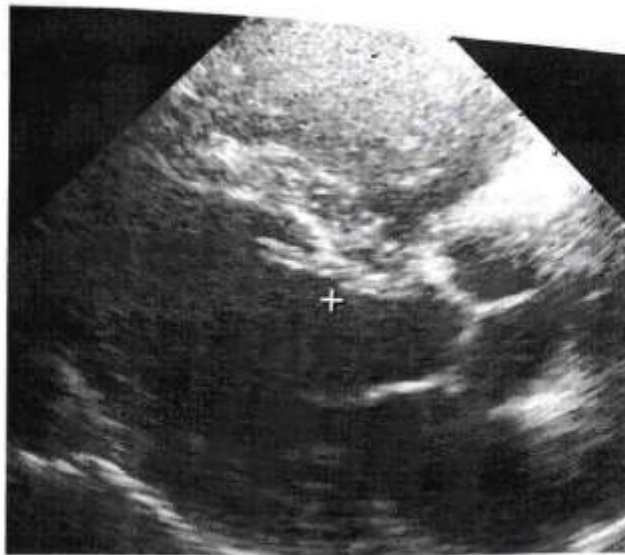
Parasternal long-axis view on a transthoracic echocardiogram of patient 1. Note the subaortic implantation of a false tendon, with a prominent localized hypertrophic response.
